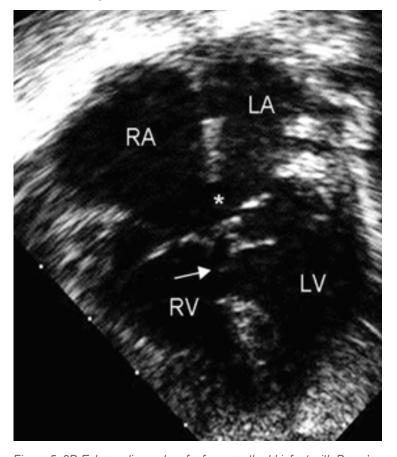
2D Echocardiography of a four-month old infant with Down's Syndrome showing Atrioventricular septal defect. (*) primum septal defect. (Arrow) inlet ventricular septal defect.
